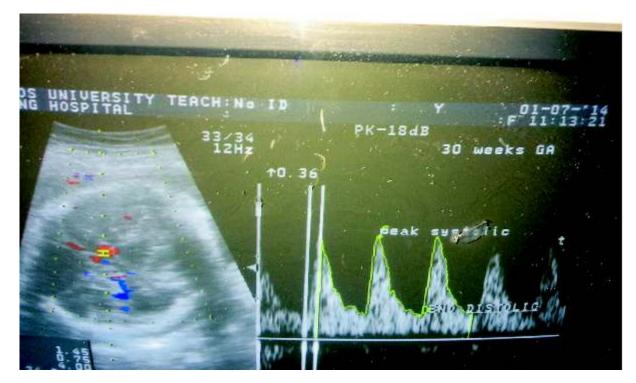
Doppler sonogram showing normal spectral Doppler waveform measurement of the foetal middle cerebral artery at 30 weeks of gestation and measurements of Doppler parameters in normal pregnancy. MCA (red colour)= middle cerebral artery, PSV=peak systolic velocity, EDV=end diastolic velocity.
